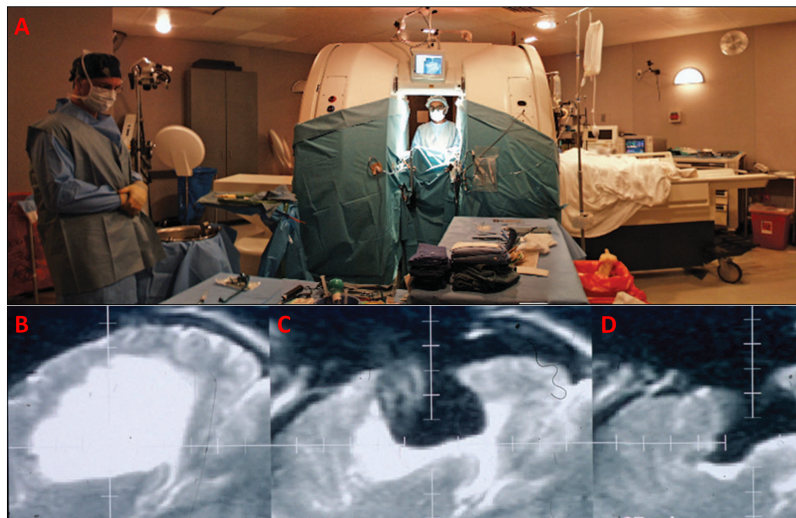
Images from [101] show the first designed intra-operative MRI in 1994 (A) and exemplary images of a glioma contrasted with Gd-DPTA in three different stages of a surgery (B-D). Figures reproduced with permission of Taylor and Francis.
